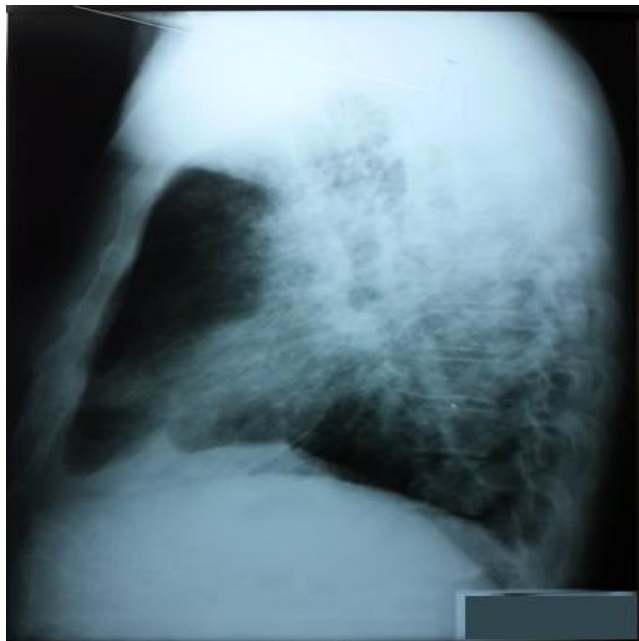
RTG lateral view: Chest X-ray found a massive, diffuse lung consolidation, with reactive hila
